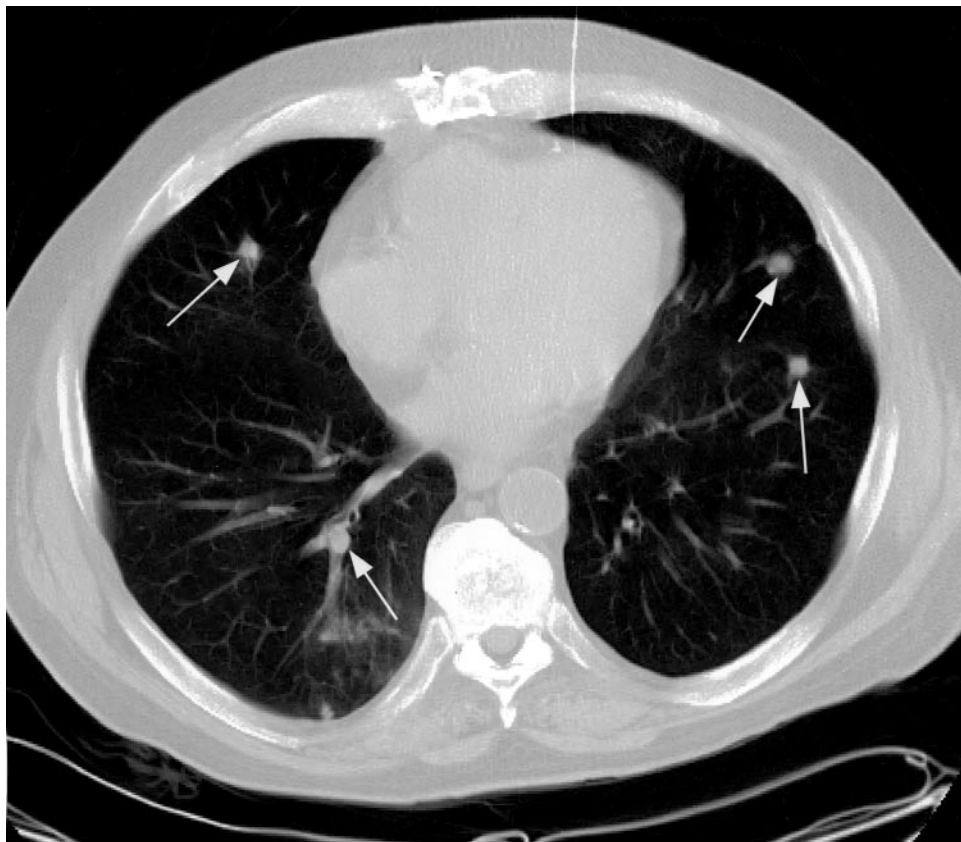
Axial section of chest CT scan without contrast reveals multiple subcentimeter pulmonary nodules without associated hilar or mediastinal lymphadenopathy (arrows).
